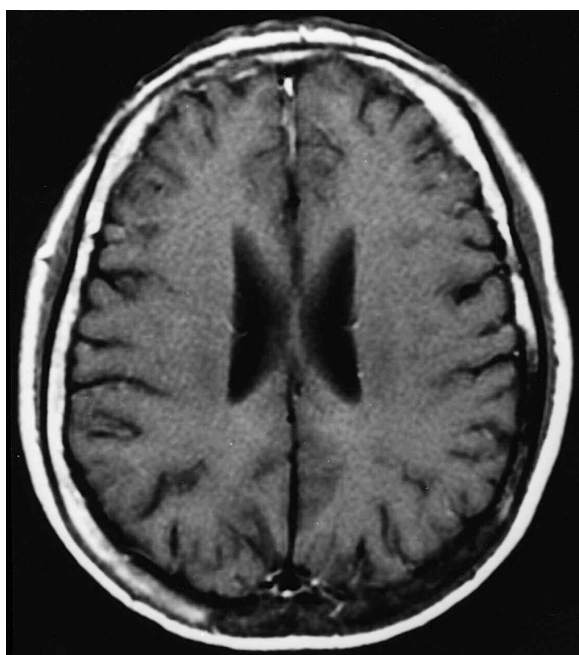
Follow up MR imaging 12 months after embolization showing. A disappearance of abnormalities of the cranium and dura.
